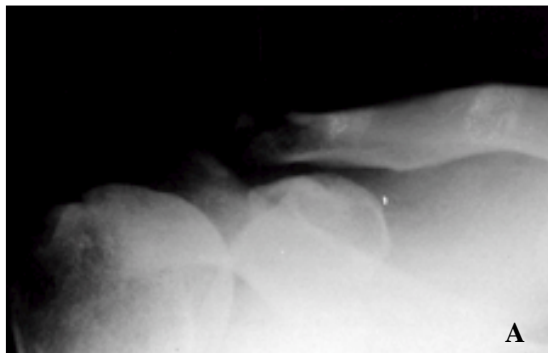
1A. Anteroposterior radiograph of the right clavicle of a 58-year-old man. The fracture showed relative large fragment and short oblique fracture pattern.
